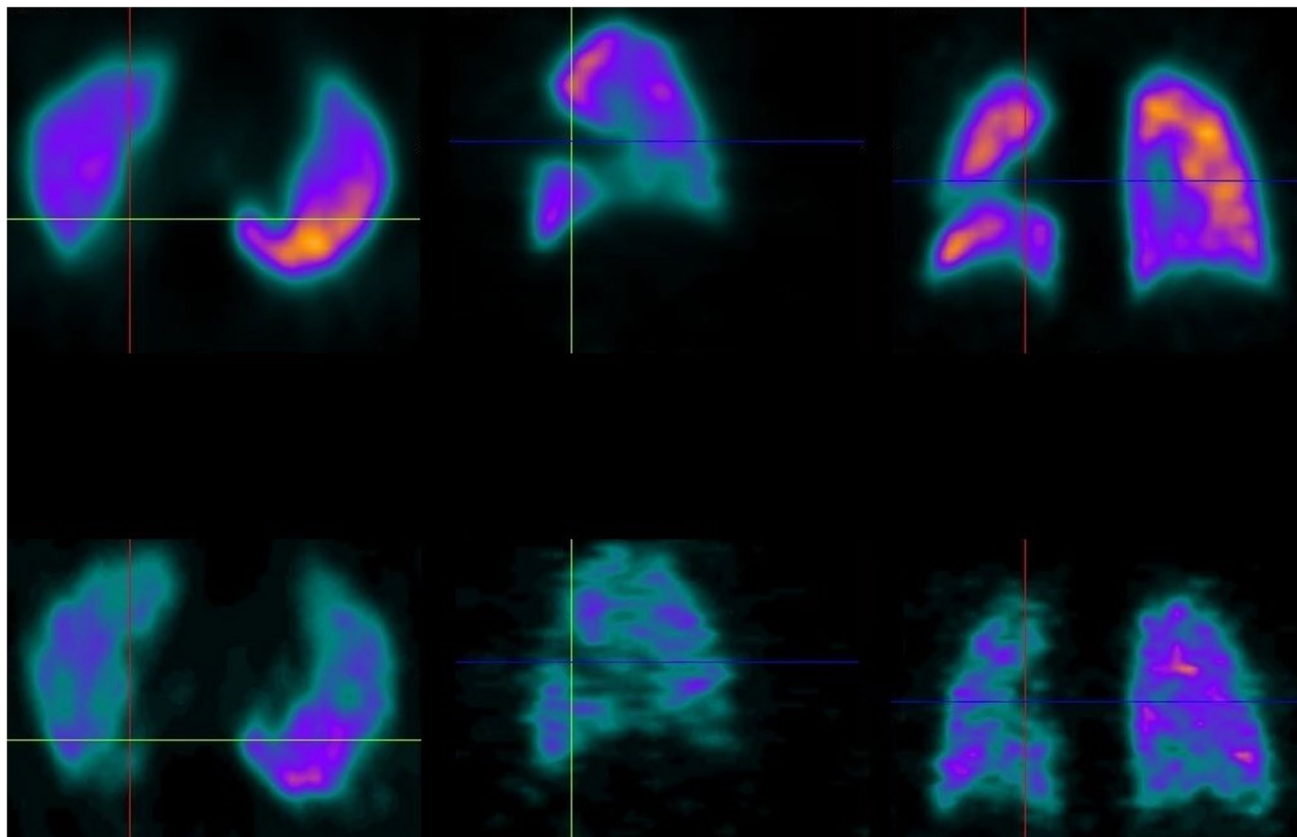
Perfusion SPECT (above) and ventilation SPECT (below) of the same patient in Fig. 1 a, performed a year after the baseline study shows persistence of the perfusion defect, which is matched on the ventilation images
